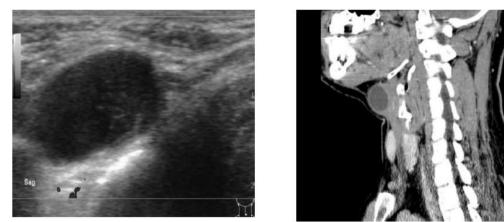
2 showing USG and CT scan images in a patient with thyroglossal cystTable : 4 Extent of the thyroglossal duct
